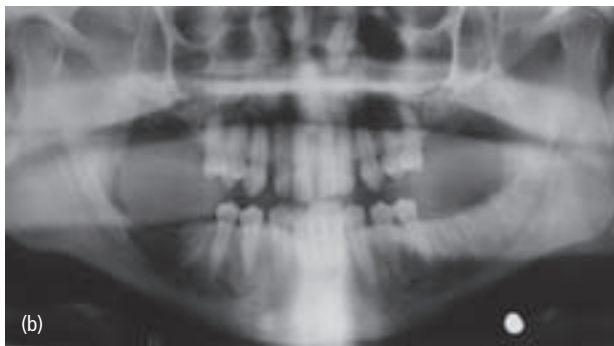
Osteoradionecrosis: 53-year-old African-American male with history of squamous cell carcinoma of the tongue. The patient was treated with surgical removal of the lesion followed by 62 Gy of radiation to the right mandible, tongue, and floor of mouth. (a) Patient presented with pain and exposed bone in right posterior mandible; osteoradionecrosis arose spontaneously, with no precipitating trauma or dental treatment; (b) radiograph shows diffuse radiolucency in right posterior region. The patient responded poorly to treatment and eventually required mandibular resection. (Courtesy of Dr Wendell Edgin, San Antonio, Texas.)
